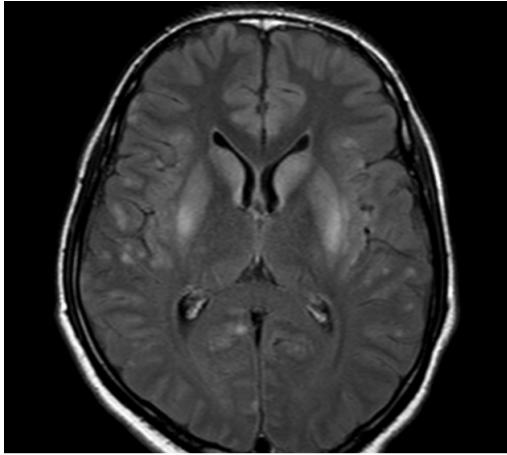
Symmetrical FLAIR Hyperintensities in bilateral Basal Ganglia(Putamen & Caudate)
